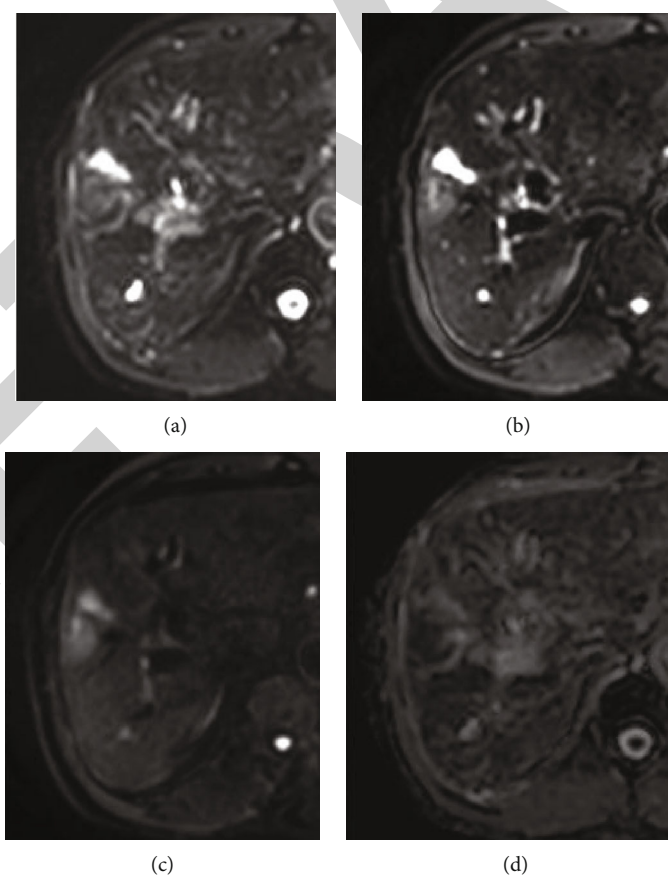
MRI image of hepatocellular carcinoma. (a: T2WI; b: T1WI; c: DWI; d: ADC).
